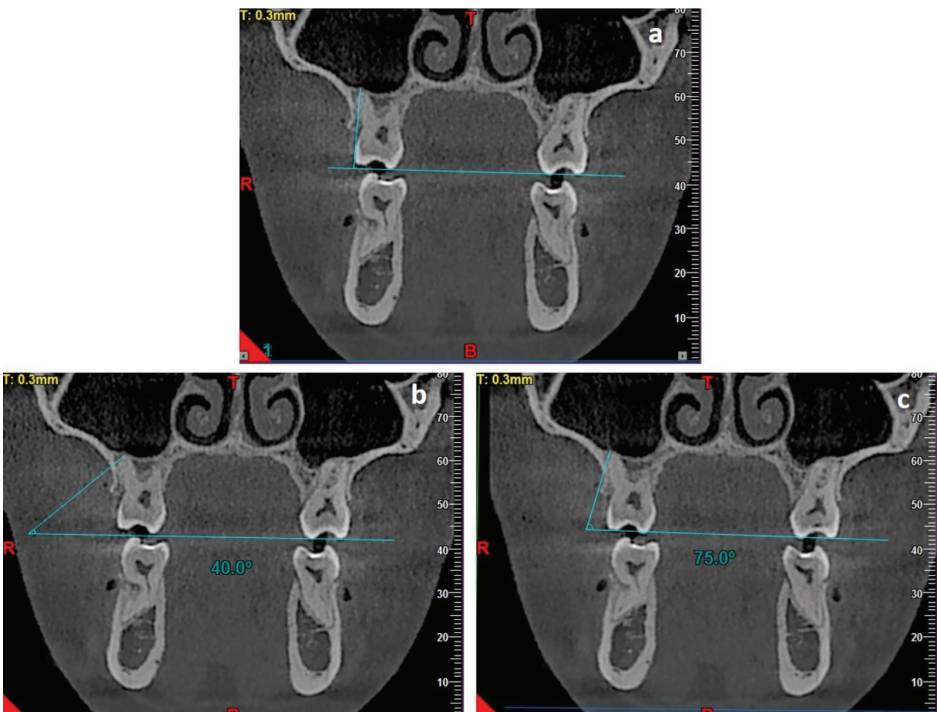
Multi-planar reconstructed CBCT images depicting the coronal sections of 0.3 mm thickness with reference plane contacting the mesio-buccal cusps of maxillary first molars. a) The orientation of the CBCT images according to the predefined reference planes for analyzing different linear measurements. b) the linear measurement of the infra zygomatic crest at 40 degrees from the reference plane. c) the linear measurement of the infra zygomatic crest at 75 degrees from the reference plane
